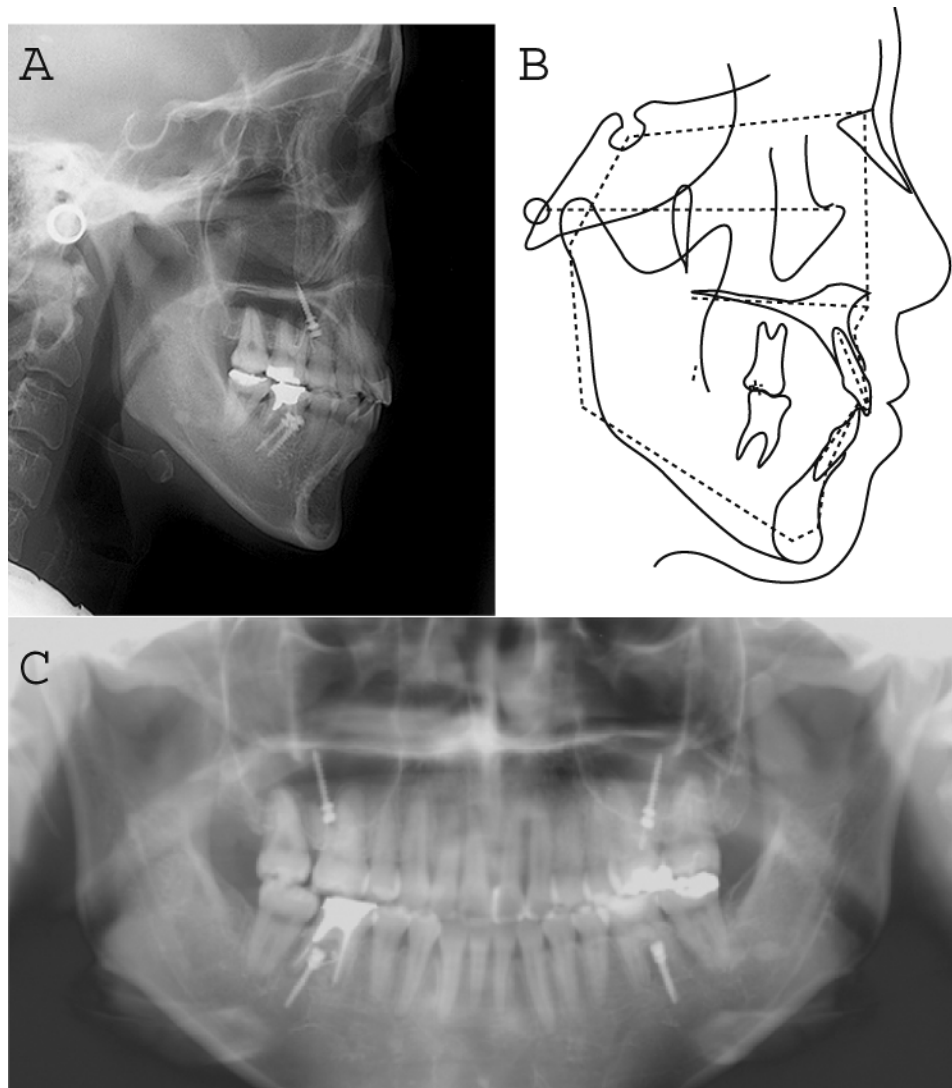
(A) Postactive treatment cephalograph. (B) Tracing. (C) Panoramic radiograph. Tracing (solid lines) was superimposed with the mean profilogram (dotted line).
